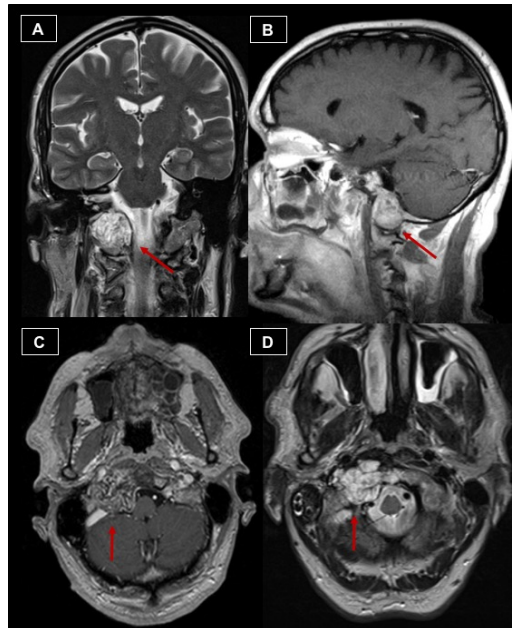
Coronal T2-weighted (A), sagittal T1-weighted post-contrast (B), axial T1-weighted post-contrast (C) and axial T2-weighted (D) MR images showing a chordoma (red arrows) involving jugular foramen.
